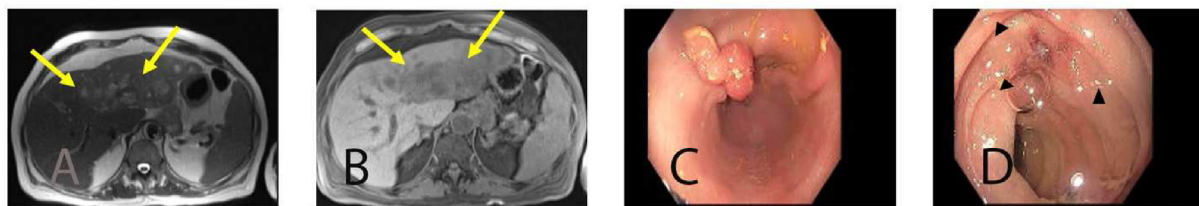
A and B are axial T2-weighted and T1-weighted post-contrast abdominal MRI images demonstrating multiple, centrally necrotic, peripherally enhancing, ill-defined, mass lesions in the liver (yellow). C and D are upper endoscopy images showing non-malignant appearing nodule in the gastric antrum and multiple superficial ulcers in the third part of the duodenum respectively.
